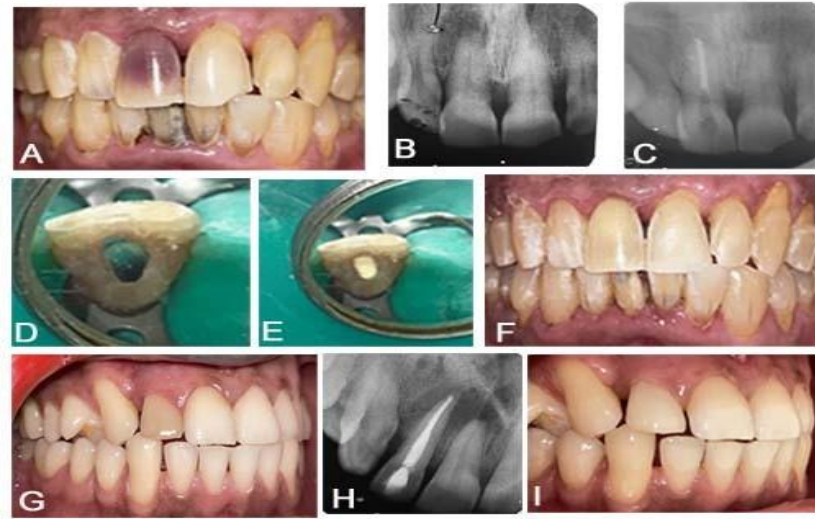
(Case 1: A-F). A. Pre-operative view, B. Pre-operative IOPAR, C. Post-endodontic IOPAR, D. Acid-etch with 37% Phosphoric acid in pulp chamber, E. Placement of Bleaching agent (sodium perborate + 30% Hydrogen peroxide) in pulp chamber, F. Post-bleaching clinical photograph. G. Case 2, Pre-operative view, H. Pre-operative IOPAR and I. Post-bleaching clinical photograph. (IOPAR: Intra-oral periapical radiograph)
